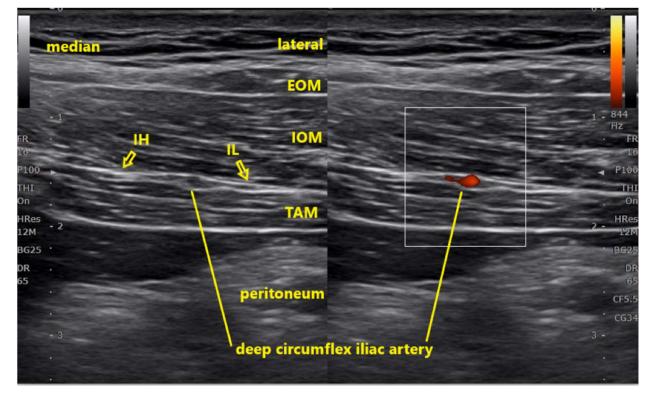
Ultrasound anatomy of the abdominal wall layers. EOM, external oblique muscle; IOM, internal oblique muscle; TAM, transverse abdominis muscle; IH, iliohypogastric nerve; and IL, ilioinguinal nerve
